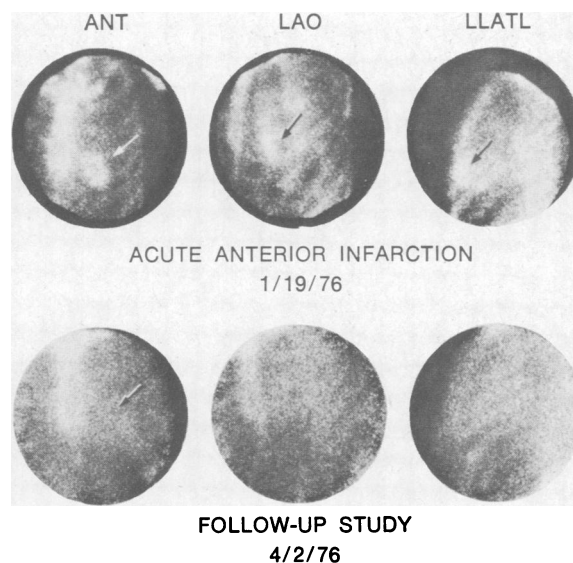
Remnant diffuse uptake. Above (upper panel) are the TcPYP scintigrams in the anterior (ANT), left anterior oblique (LAO) and left lateral (LLATL) projections done at the time of acute anterior infarction. The scintigram is abnormal with a 4+ discrete anterior accumulation (arrows). In the lower panel are scintigrams done in the same patient three months later. The patient was asymptomatic at the time of repeat study, but a poorly localized 2+ diffuse pattern of radionuclide uptake was noted.
